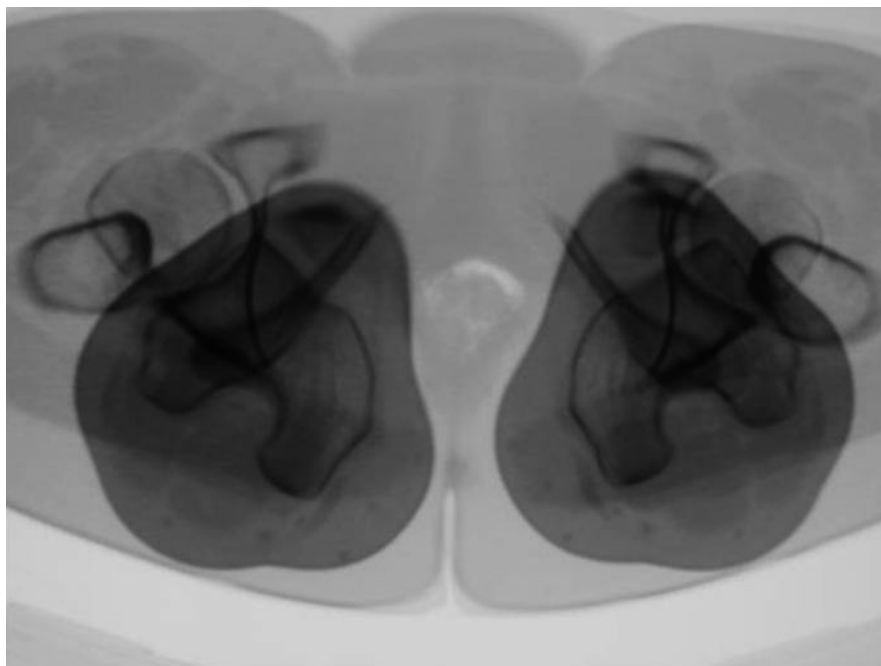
In the patient with marked increase in external tibial torsion, a standing radiograph with the patella pointing forward shows the os calcis medial to the ankle joint, an oblique view of the talus and a near lateral view of the foot
